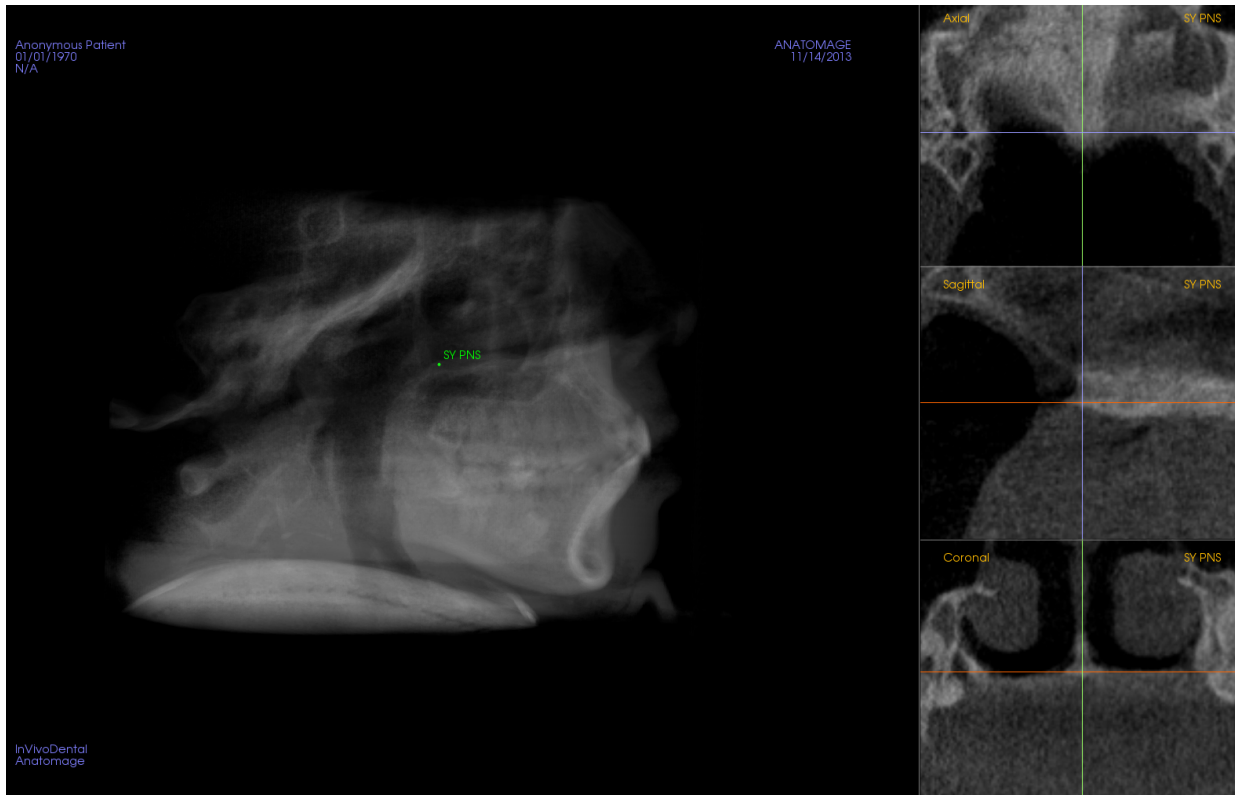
PNS, due to being an internal structure, is easier to perform initial tracing on sagittal radiograph than on volumetric rendering.
